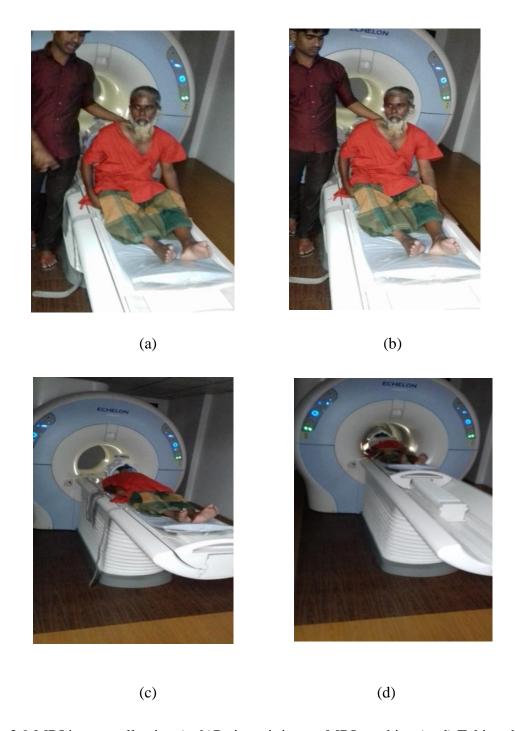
MRI image collection (a+b)Patient sitting on MRI machine,(c+d) Taking the image of the patient
